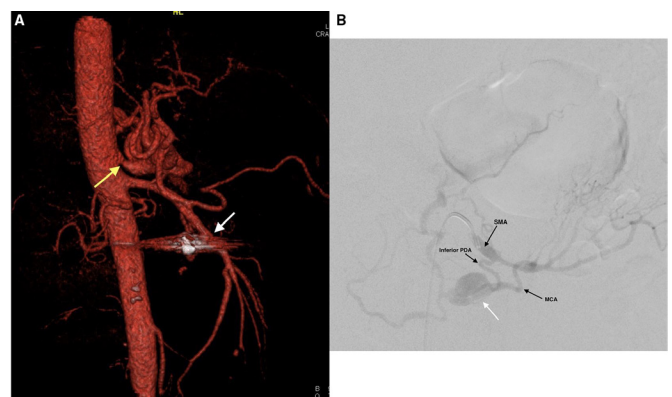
(A): Three-dimensional CT recon (Sagittal view) showing coeliac axis stenosis (yellow arrow); inferior PDA aneurysm postangiobolisation (white arrow). (B) Angiography: aneurysm (white arrow) along inferior PDA. MCA, middle colic artery; PDA, pancreaticoduodenal artery; SMA, superior mesenteric artery.
